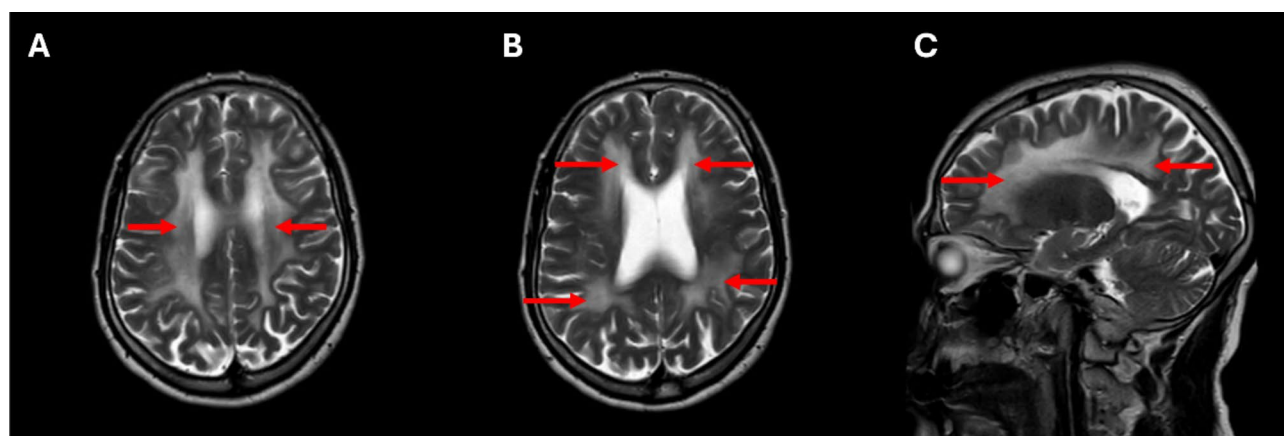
(A), (B), and (C) Axial and sagittal view of MRI revealed white matter that was diffusely involved with T2-FLAIR hyperintensity, extending from the periventricular white matter to the subcortical arcuate fibers (Red arrows)
